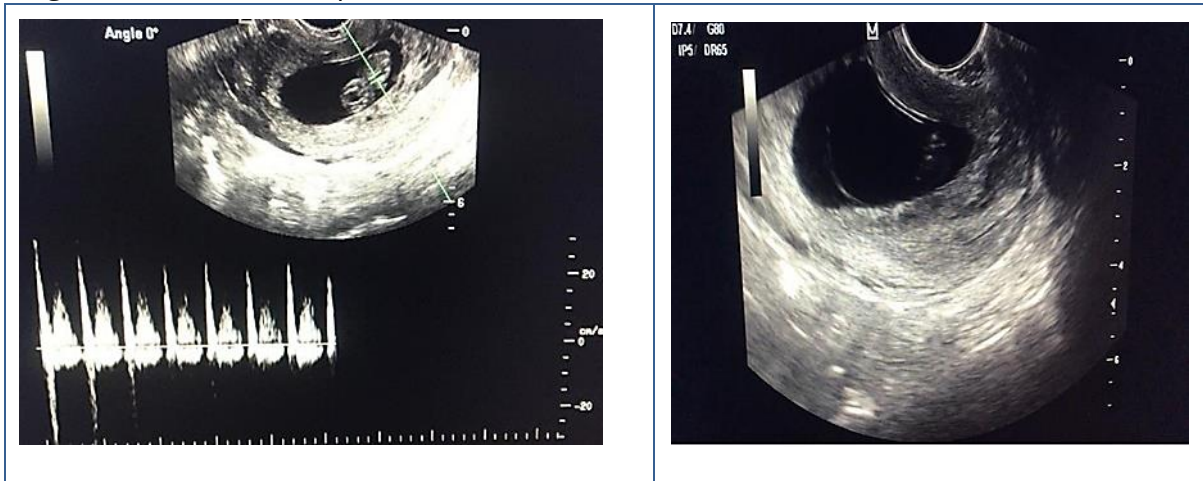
Transvaginal ultrasound on Day1: fetal pole and fetal heart beat identified below the internal os of the cervix.
